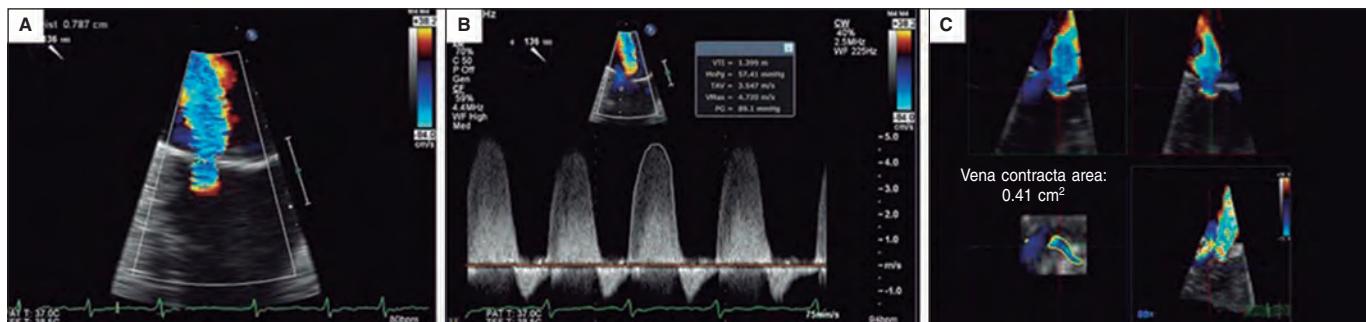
Two-dimensional transesophageal echocardiography image. A and B give an estimate of the effective regurgitant orifice area based on the proximal isovelocity surface area with a result of 0.32cm^2 . Two-dimensional estimate of the proximal isovelocity surface area: effective regurgitant orifice area = $2\pi r^2$ *aliasing velocity/mitral regurgitation peak velocity = $[6.28 \times (0.79) 2 \times 38.2]/472 = 150/472 = 0.32\text{cm}^2$. C: when the measurement is taken using the 3D-guided direct planimetry, the result is 0.41cm^2 . The 3D-guided direct planimetry gives more accurate measurements of the orifice because it eliminates the artifacts caused by indirect measurements. Reproduced with permission from Katz et al.²⁴.
